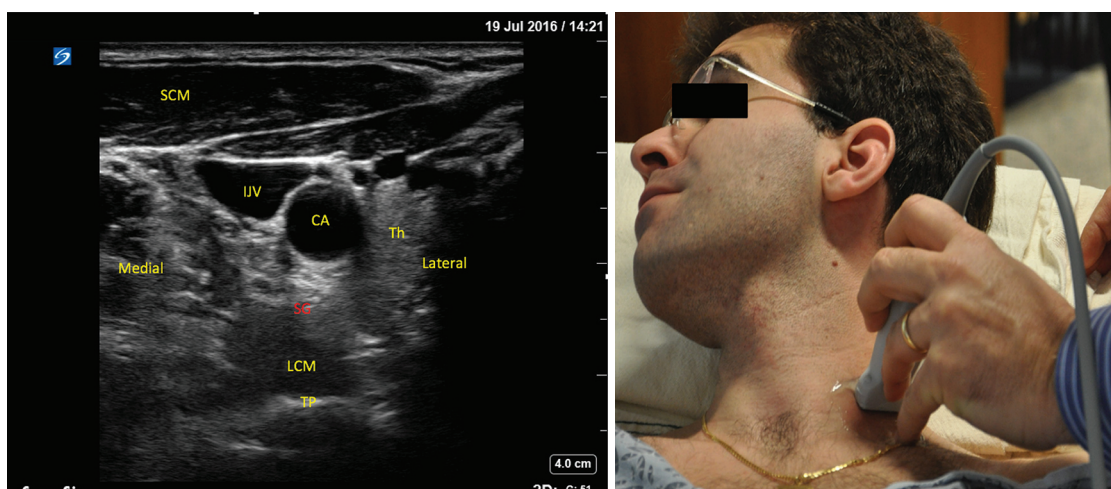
Ultrasound scanning (left) and ultrasound image for a left stellate ganglion block (right).
